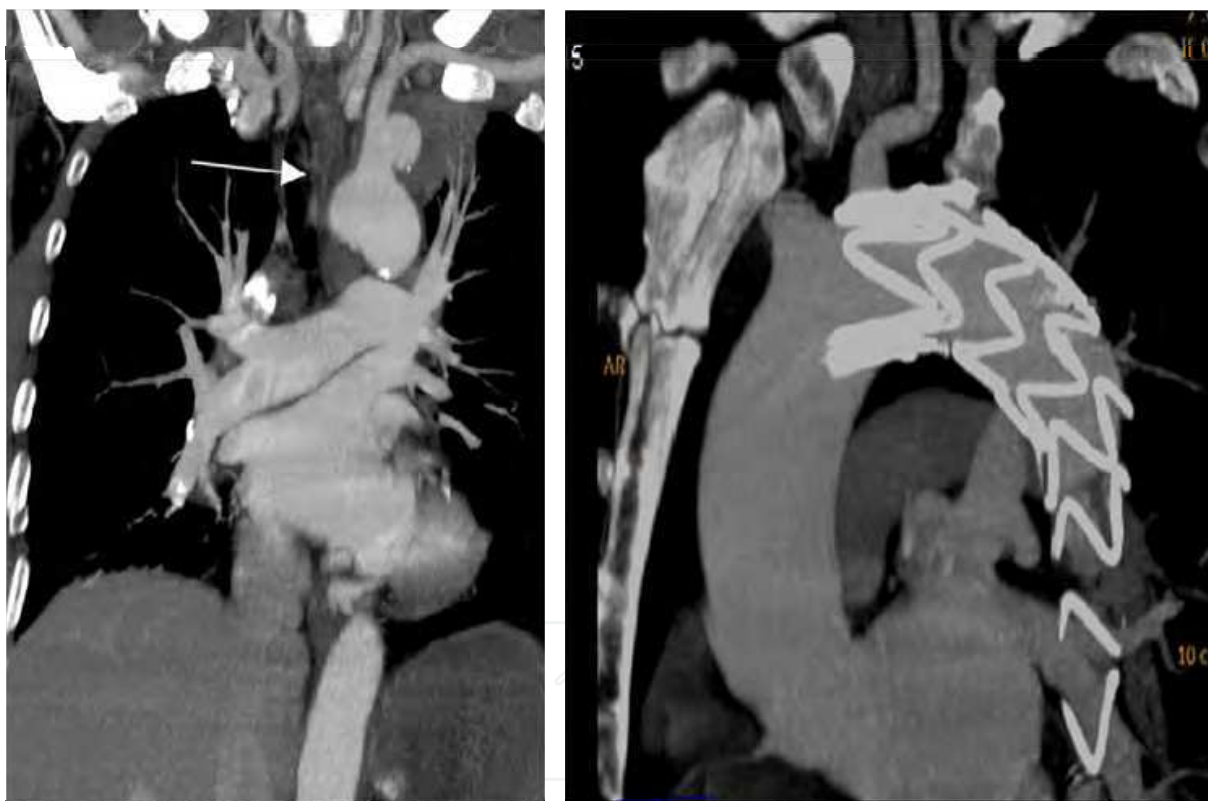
Case 25. Left: Computed tomography scan revealing a pseudoaneurysm measuring 30 mm x 20 mm (arrow) at the origin of the left subclavian artery. Right: Computed tomography scan revealing accurate placement of endoprosthesis and 16-mm Amplatzer plug, with successful exclusion of the pseudoaneurysm (right).
